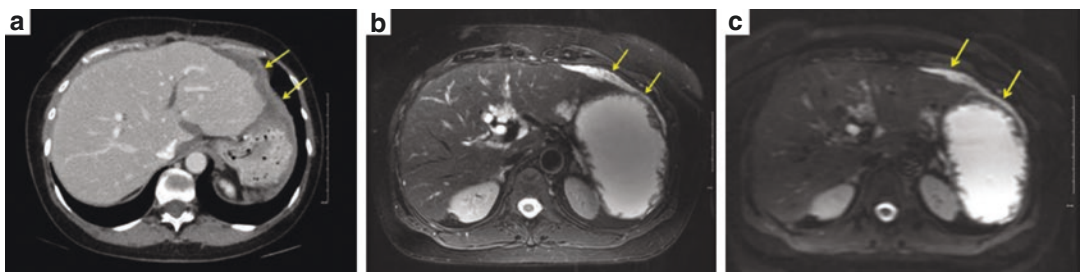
(a) Contrast-enhanced computed tomography—(arrows) low-attenuation material along the perihepatic, lesser sac, and perigastric regions representing mucinous ascites; (b) axial, T2-weighted magnetic
